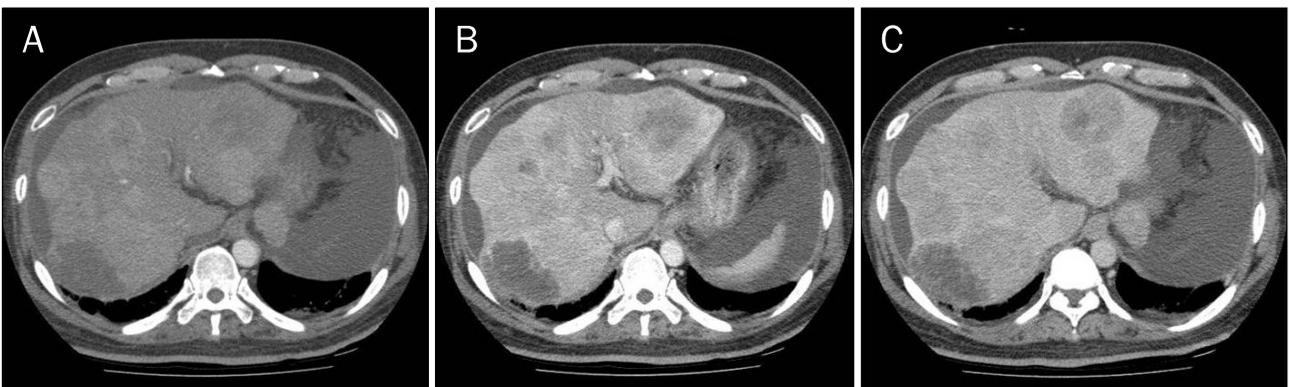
(A) Arterial phase, (B) portal phase, (C) delayed phase. Numerous hepatocellular carcinomas are seen in the entire liver on abdominal CT. These masses show heterogeneous enhancement in arterial phase and typical wash-out pattern in portal and delayed phase.
